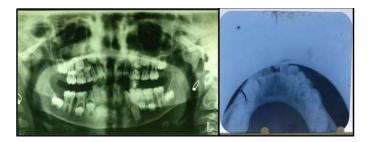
Pre operative OPG, Occlusal radiograph
